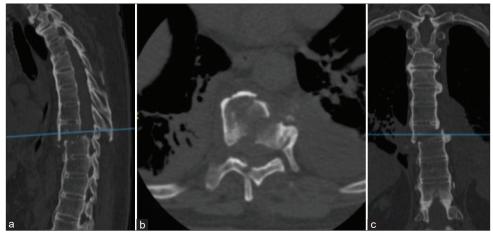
Computed Tomography Scan (a) Sagittal view (b) Axial view (c) Coronal view. lesion type C T8-T9.
